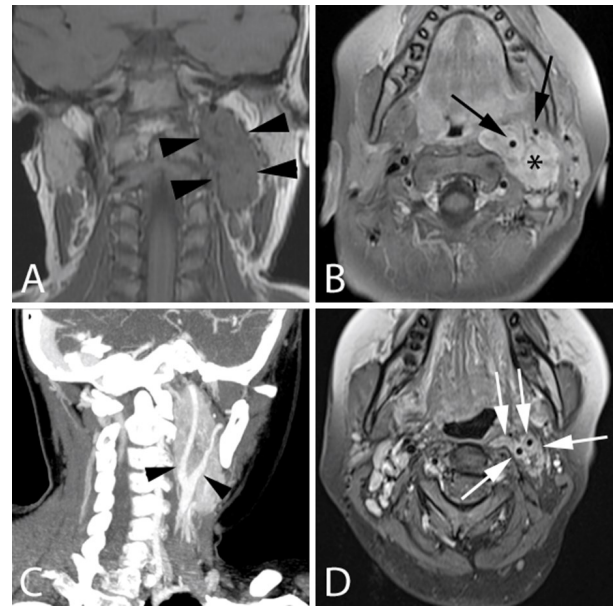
A represents a coronal T1 weighted neck MR image at the initial presentation. B is an axial fat suppressed T1-weighted post Gadolinium neck MR image, also at initial presentation. C is a CT angiographic image of the neck in maximum intensity projection (MIP) technique and parasagittal oblique reconstruction, showing the left carotid bifurcation in profile, 2 months post initial presentation. D represents a latest MR neck image in axial fat suppressed T1-weighted post Gadolinium sequence, 4 years after initial presentation. The well circumscribed mass located within the left carotid space is fusiform in shape and located high in the neck, just inferior to the skull base (black arrowheads in A). It causes partial filling of the left parapharyngeal space. Its superior margin does not extend into the ipsilateral jugular fossa. It is intensely enhancing (B and C). Several serpentine flow voids (asterisk in B) are identified within the mass (best seen in B, subtly appreciated in A). The mass does extend to the carotid bifurcation (and for a short distance below the bifurcation, C). Note the slight splaying apart of the left internal and external carotid arteries (black arrows in B, black arrowheads in C). The normal right internal and external carotid arterial distance in B may be used as a comparison .
